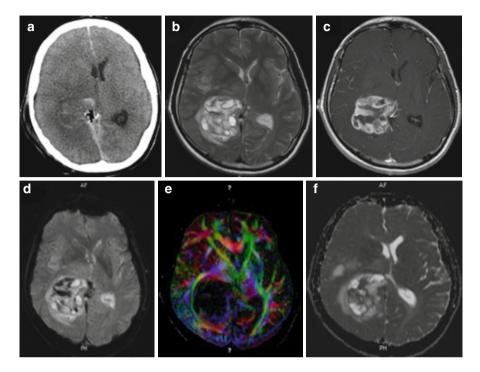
Images of a patient with new onset of aura symptoms and headache: *top row* (\mathbf{a} - \mathbf{c}) shows CT scan unenhanced (\mathbf{a}), T2-weighted MR image (\mathbf{b}), and T1-weighted contrast-enhanced MR image (\mathbf{c}); *bottom row* (\mathbf{d} - \mathbf{f}) shows diffusion and perfusion-weighted MR image (rCBV) and ADC image. Perfusion-weighted image demonstrates rCBV elevation indicative of high-grade glioma. ADC values in more solid temporo-occipital parts are lower than in normal brain tissue, indicating higher cellularity. Final diagnosis was glioblastoma multiforme WHO IV
